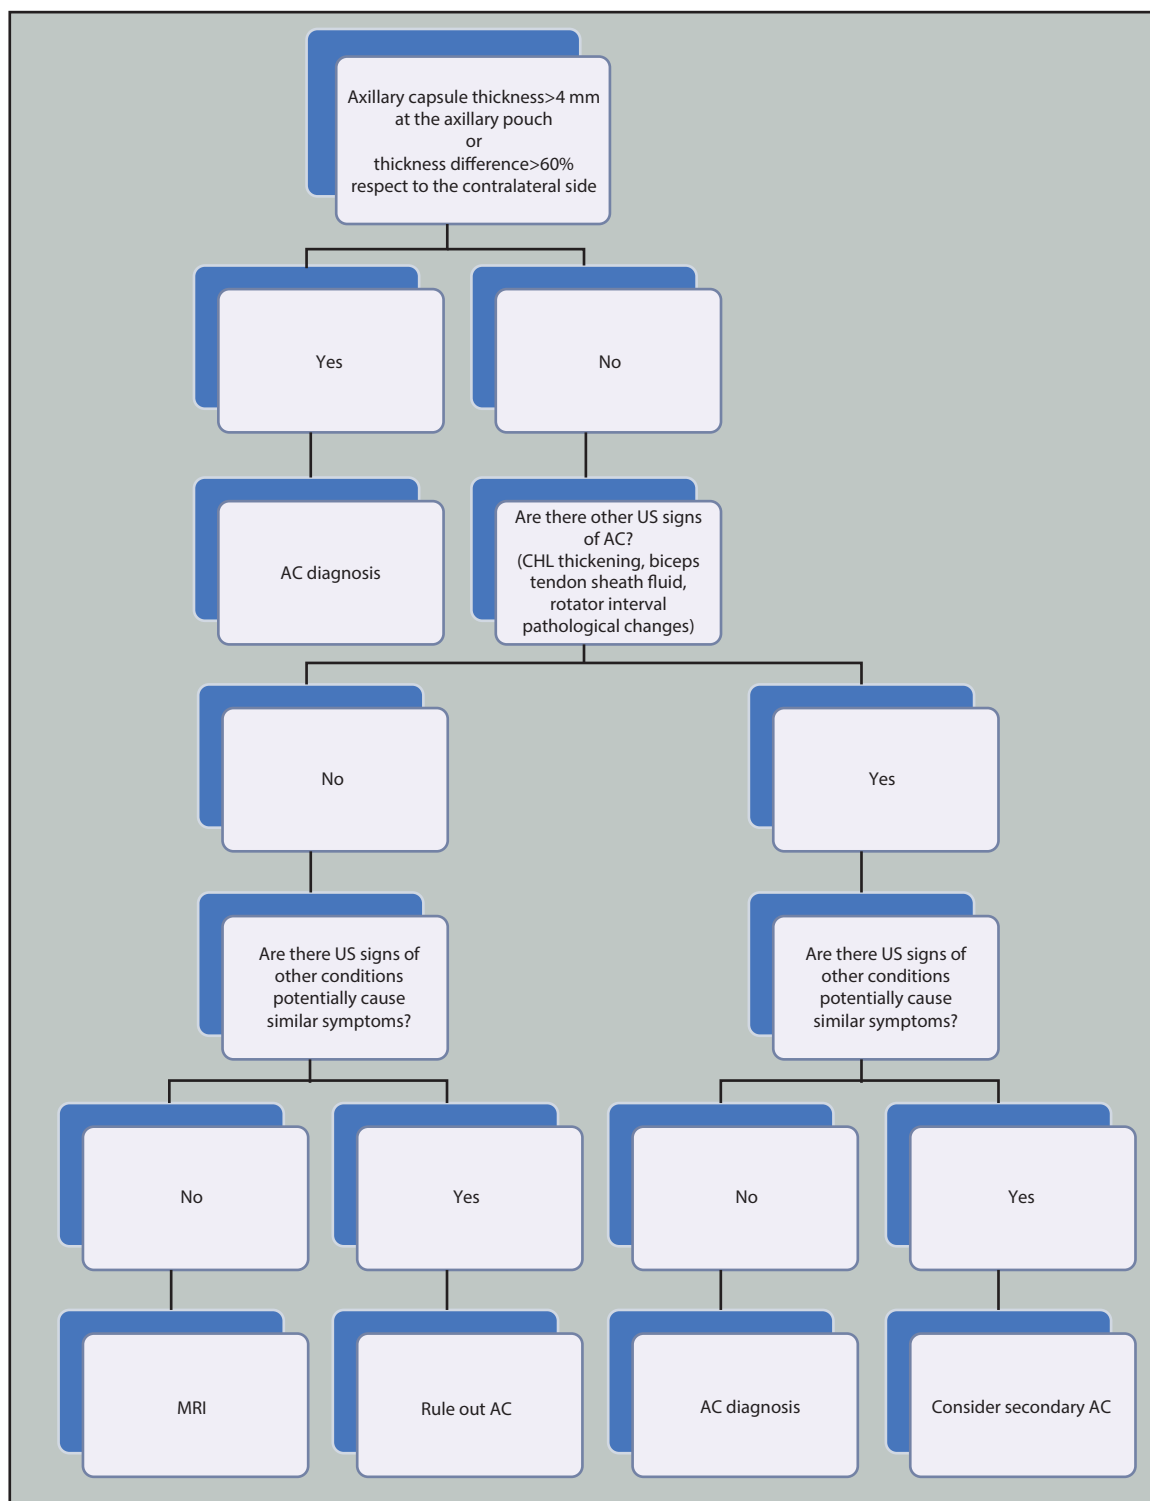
Protocol for imaging evaluation using ultrasonography in patients with adhesive capsulitis. Adapted from Picasso et al. [5] with CC-BY.
